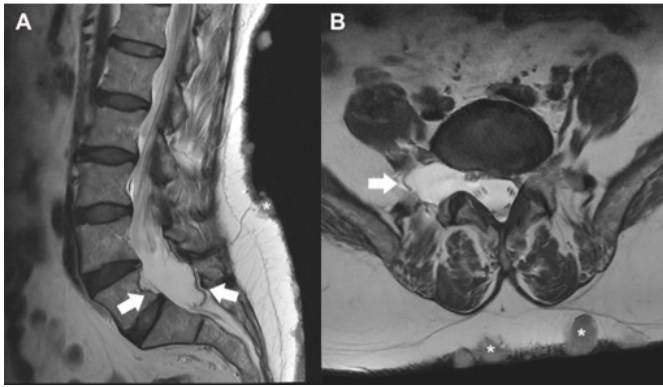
A, B. Sagittal (A) and axial (B) T2 weighted MRI images show ectasia and right paravertebral bulging of the dural sac at the level of L5 (arrows in A and B). Scalloping of the corpus was also present in the L5 vertebrae. The diagnosis was lateral meningocele associated with neurofibromatosis. Note the presence of subcutaneous neurofibromas in varying sizes (asterisks)
